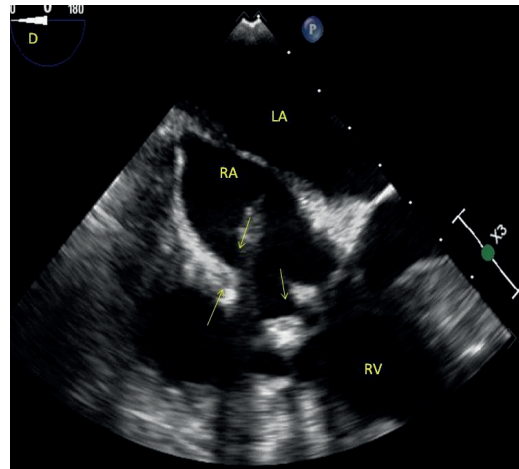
Mid-esophageal four-chamber view of transesophageal echocardiography showing looped and calcified leads (RA: Right atrium, LA: Left atrium, RV: Right ventricle).
